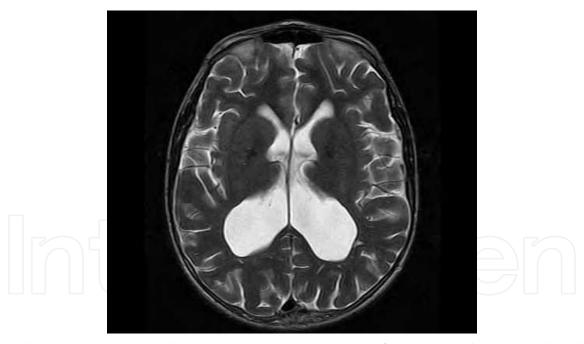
b. Post operative axial T2W MRI sequence one year after surgery showing reduced ventricular size compared to the pre-operative examination.
